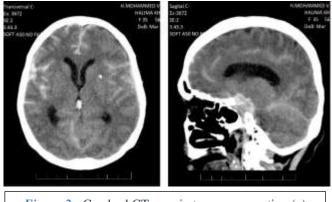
Cerebral CT scan in transverse section (a) and sagittal section (b) showing a cerebro-meningeal hemorrhage with ventricular flooding.
